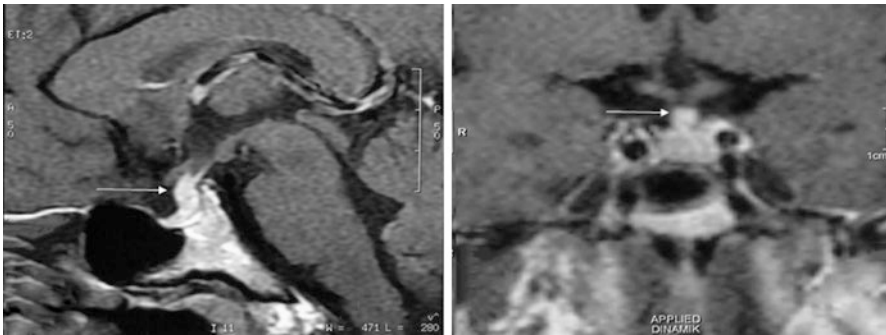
Sagittal and coronal T1-weighted images demonstrate infundibular thickening. From Valladeau J, Dezutter-Dambuyant C, Saeland S. (2003) Langerin/CD207 Sheds Light on Formation of Birbeck Granules and Their Possible Function in Langerhans Cells. *Immunologic Research*. 28(2)93–1007
